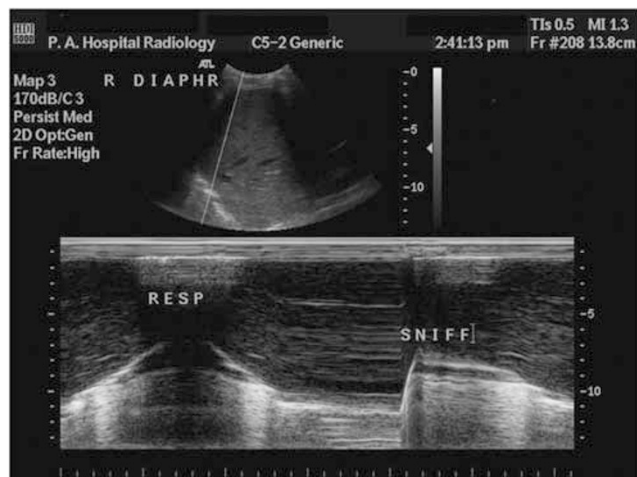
M mode ultrasound trace of normal diaphragm movement. In a normal diaphragm a sharp upstroke is demonstrated when the patient sniffs
